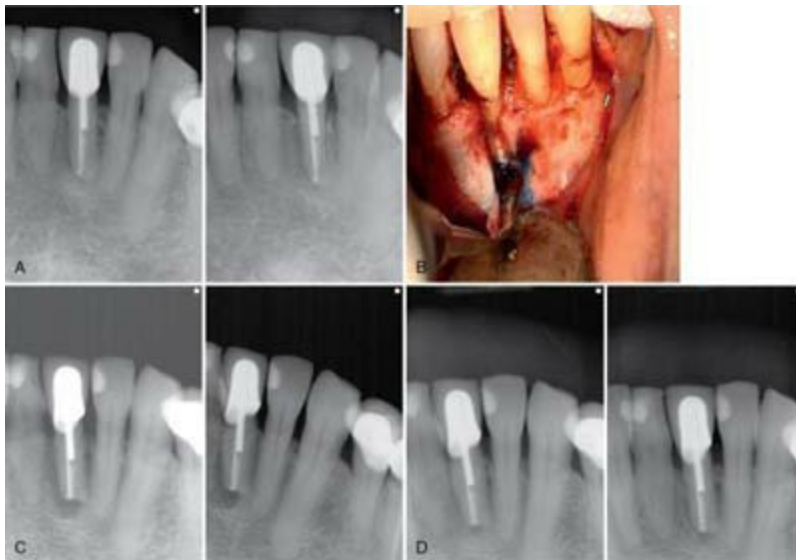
Cemental tear. A, Radiographs revealed an endodontically treated tooth with post, separated instrument, and apical osseous
